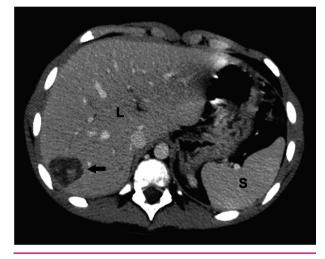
Follow-up abdominal CT in patient #2 six months after the first CT scan demonstrates significant resolution of the hepatic lesions with a single residual lesion in segment 7 of the liver (arrow). The lesion shows internal enhancement, depicting its vascular nature. L=liver; S=spleen
